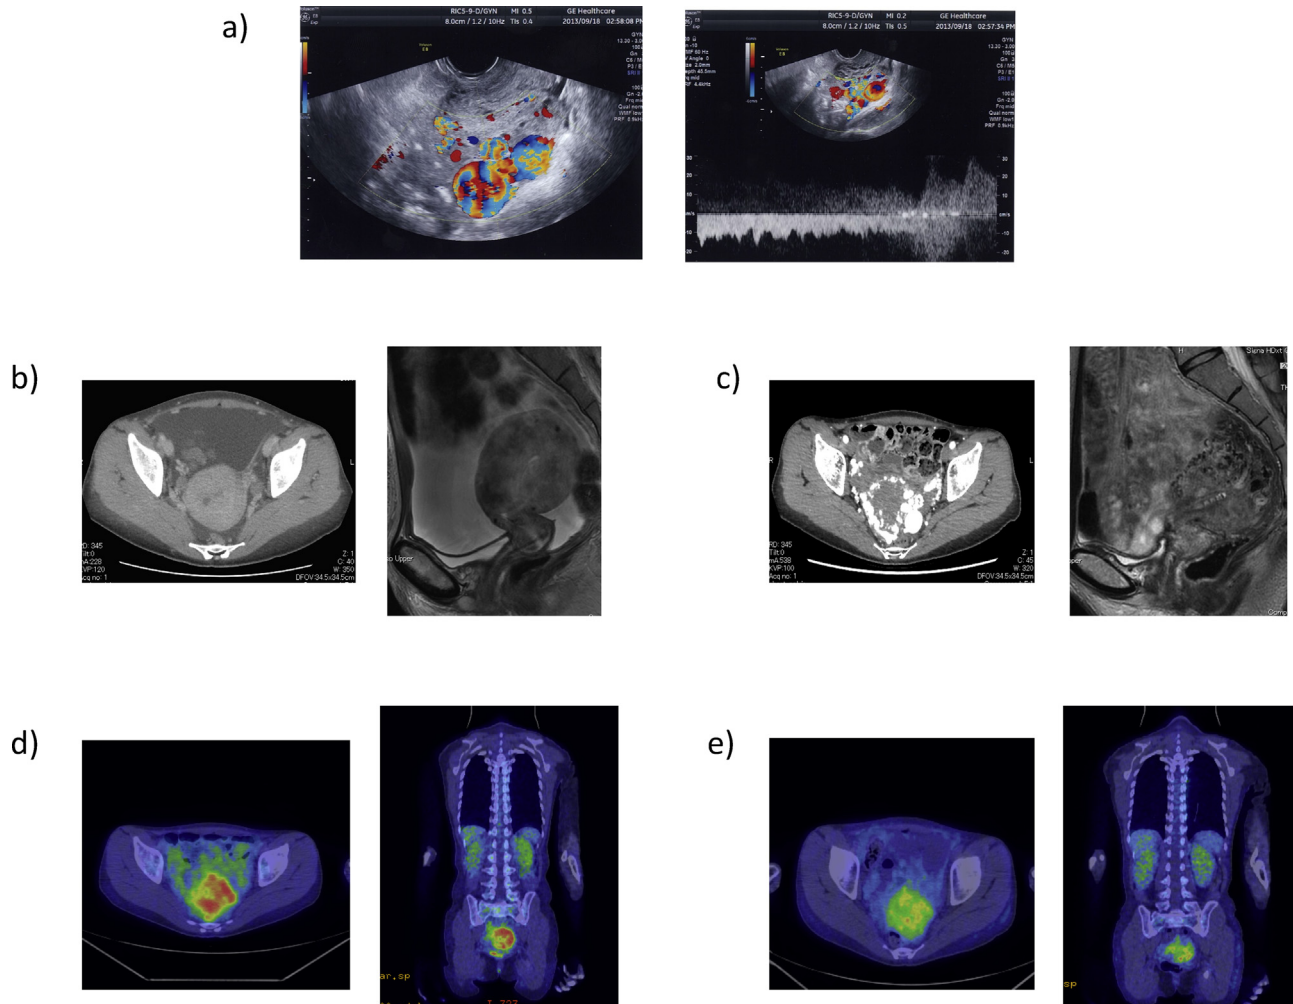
(A) Before total hysterectomy, transvaginal color Doppler ultrasound revealed an enlarged uterus filled with a hypervascular mass in the endometrium and myometrium. (B) Before MTX therapy, CT and MRI showed an enlarged uterus, but the tumor was not found clearly in the uterus. (C) Before total hysterectomy, CT and MRI revealed an enlarged uterus filled with a hypervascular mass in the endometrium and myometrium, enlarged vessels in the myometrium, and enlarged gonadal vessels. After MTX treatment, repeat PET-CT showed uptake in the accumulation images, but there was a clear decrease in maximum standardized uptake value. (D) Before MTX treatment; (E) after MTX treatment. CT = computed tomography; MRI = magnetic resonance imaging; MTX = methotrexate; PET = positron emission tomography.
